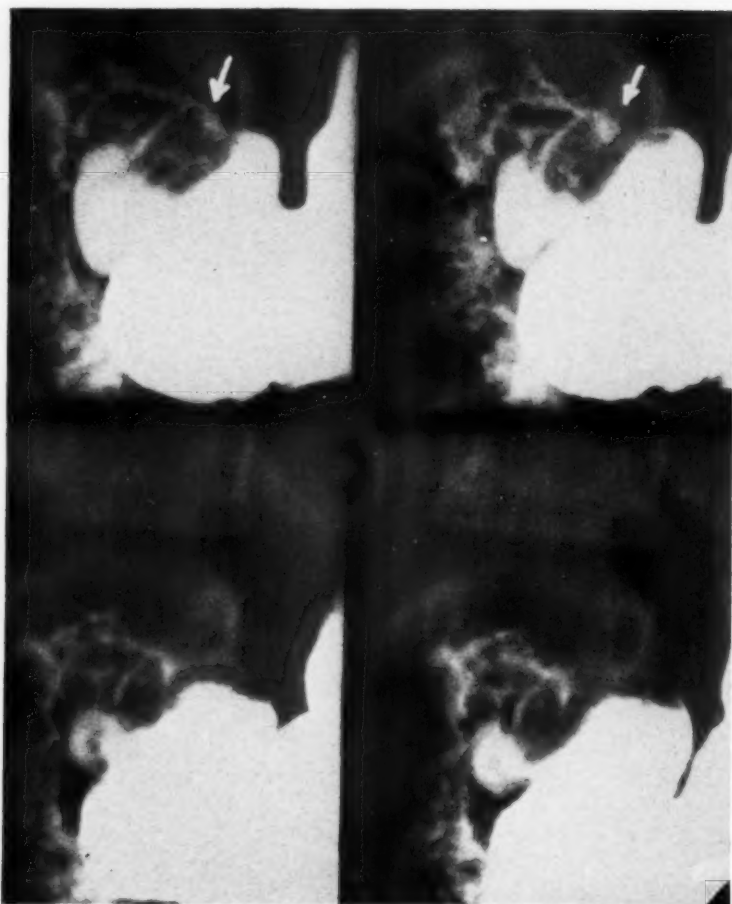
Eleven-year-old boy who had complained of abdominal pain and nausea, but without vomiting, for many months. There was considerable spastic constipation, and eating was difficult because of nausea. Appendectomy eight months previous to x-ray examination did not relieve pain. The bulb is markedly deformed, with a prominent mucosal pattern and a persistent defect, suggesting an ulcer niche, at the base on the lesser curvature.
